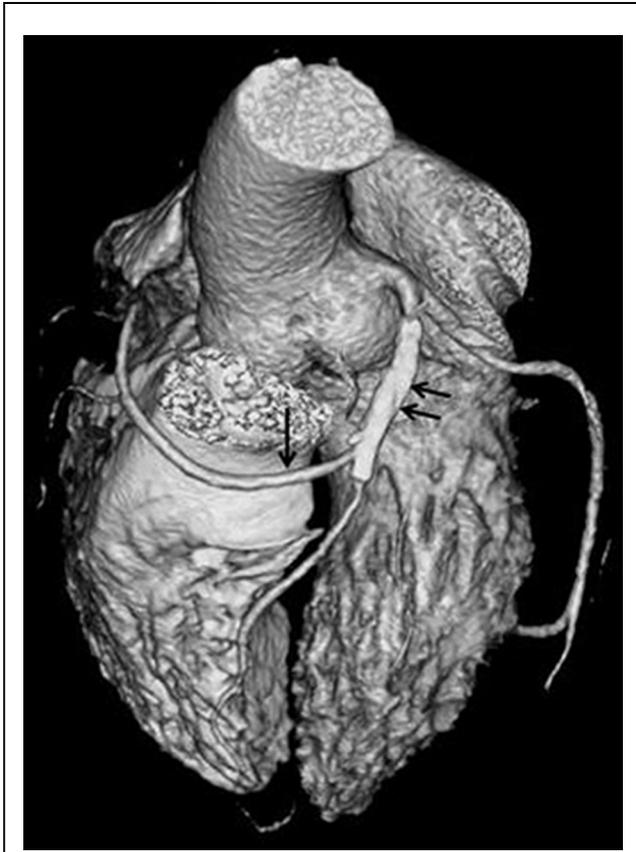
CT Coronary Angiogram (Post-Angioplasty) Showing the Anomalous RCA From the Mid-LAD
